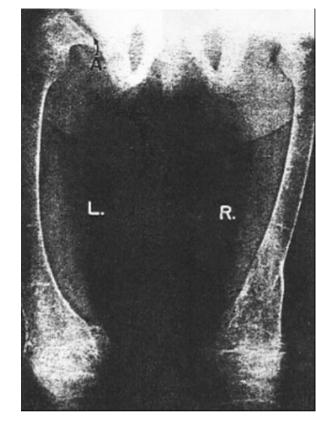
Radiograph of both femurs before starting treatment in the patient in Fig. 5.1 [5]
